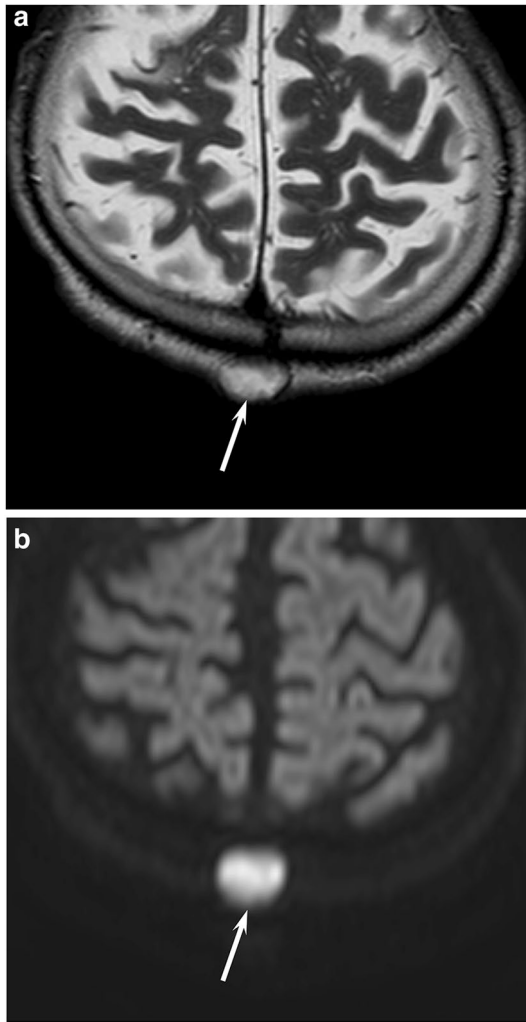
A 56-year-old man with epidermoid cyst. a T2-weighted image shows a well-demarcated, heterogeneously hyperintense, subcutaneous lesion (arrow). b Diffusion-weighted image shows intense hyperintensity (arrow)
